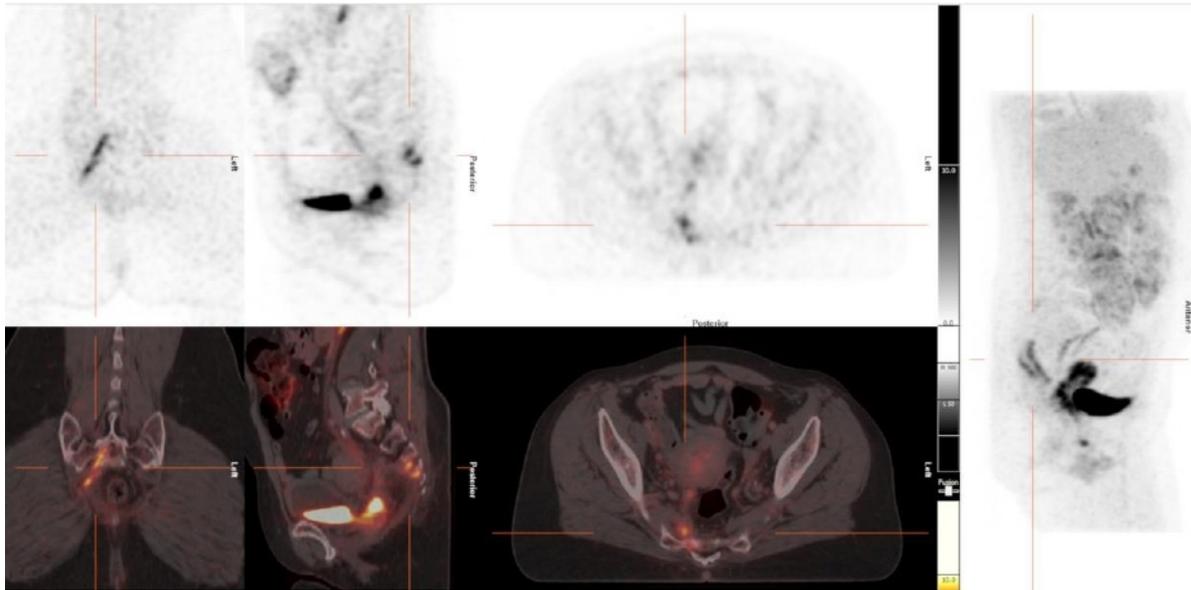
PET-CT images of a 63-year-old woman, initial stage IIIB squamous cell carcinoma of the cervix, HIV negative. Imaging findings included nodal uptake, lung metastases, and infiltration of the right sacral nerve. The patient received palliative pelvic radiotherapy and was started on palliative chemotherapy. CT, computed tomography; PET, positron emission tomography.
